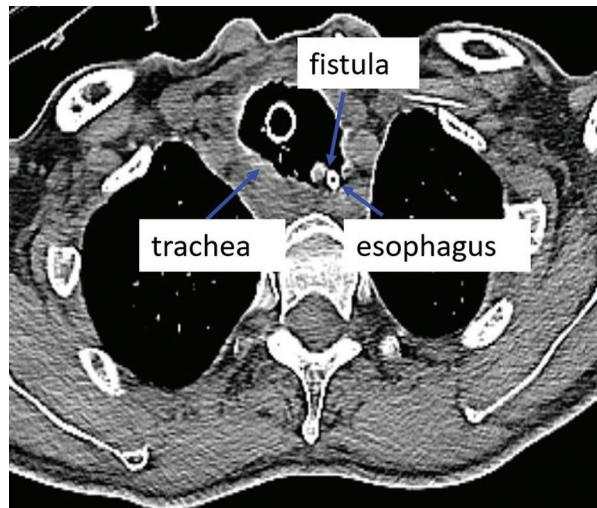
Trachea and fistula in the chest computed tomography.
